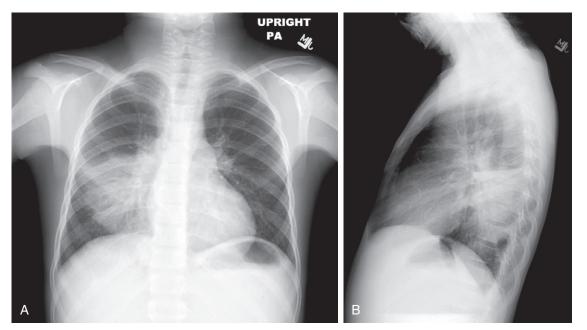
Pneumonia. A, Posteroanterior view and B, lateral view of *Mycoplasma* pneumonia in a 10-year-old boy. Posteroanterior chest radiograph shows right lower lobe (apical segment) involvement of a lobar infiltrative process.
